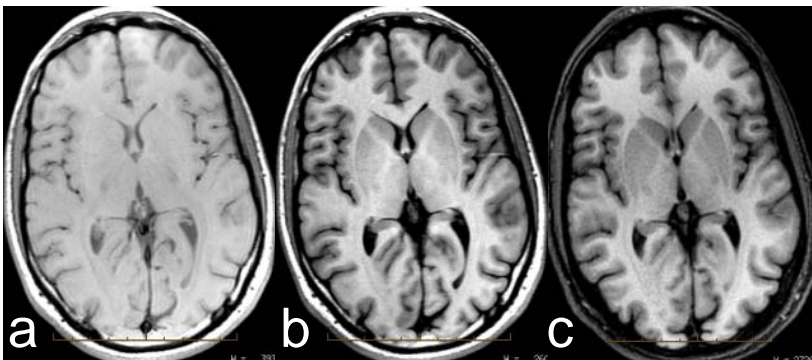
Volunteer data acquired with (a) T1 SE, (b) T1 FLAIR, and (c) T1 FLAIR PROPELLER, respectively.
